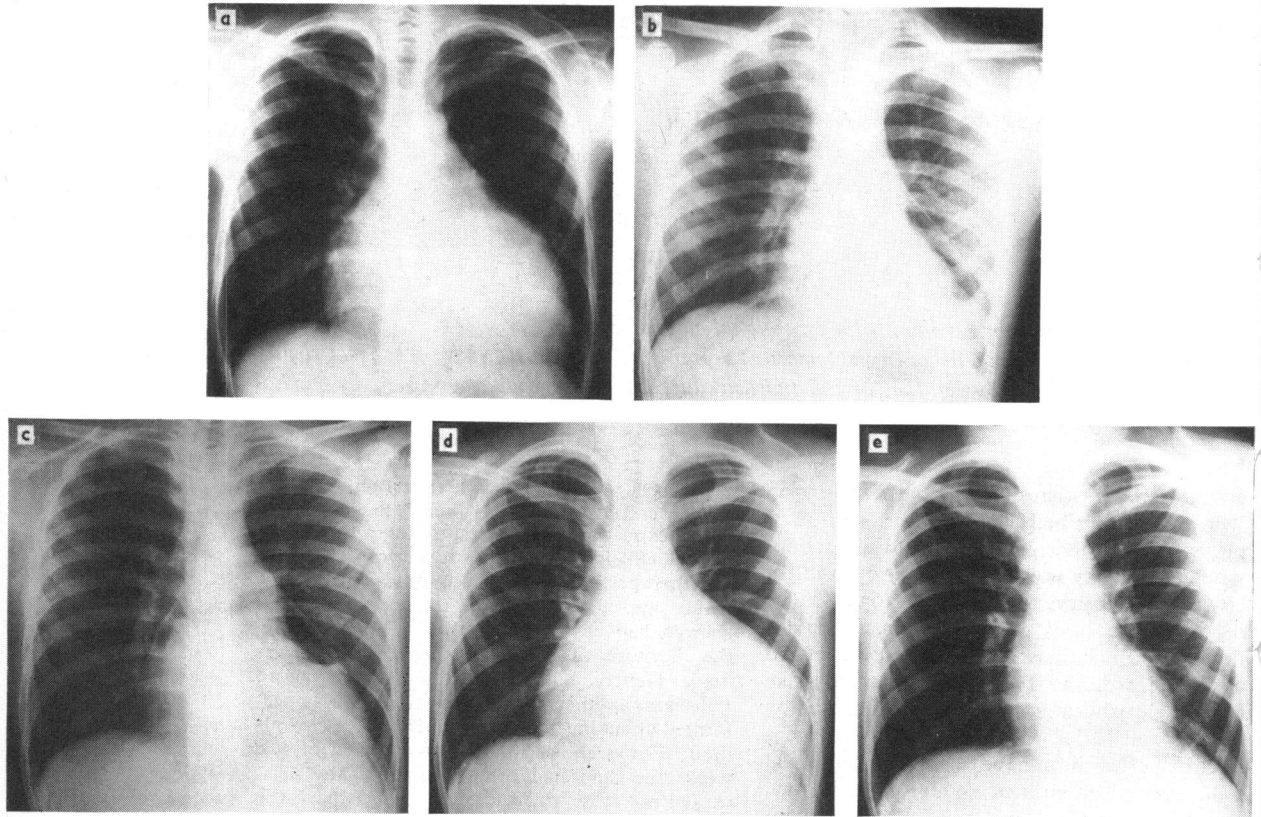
Chest x-rays: (a) On admission; (b) after pericardiocentesis; (c) 3 days after pericardiocentesis; (d) 2 weeks after pericardiocentesis; and (e) 9 months postoperatively.
